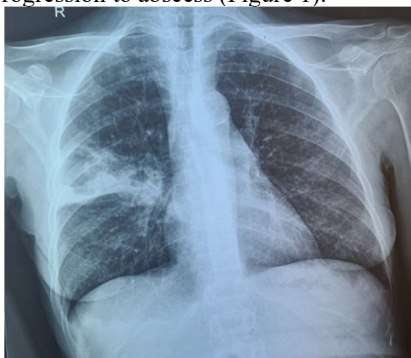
Chest radiography revealed triangular opacity with dimensions of 55/81.1mm located in the ventral segment, right upper lung lobe, with diffuse upper contour, delimited by horizontal fissure with inhomogeneous structure due to the presence of transparent areas inside.
